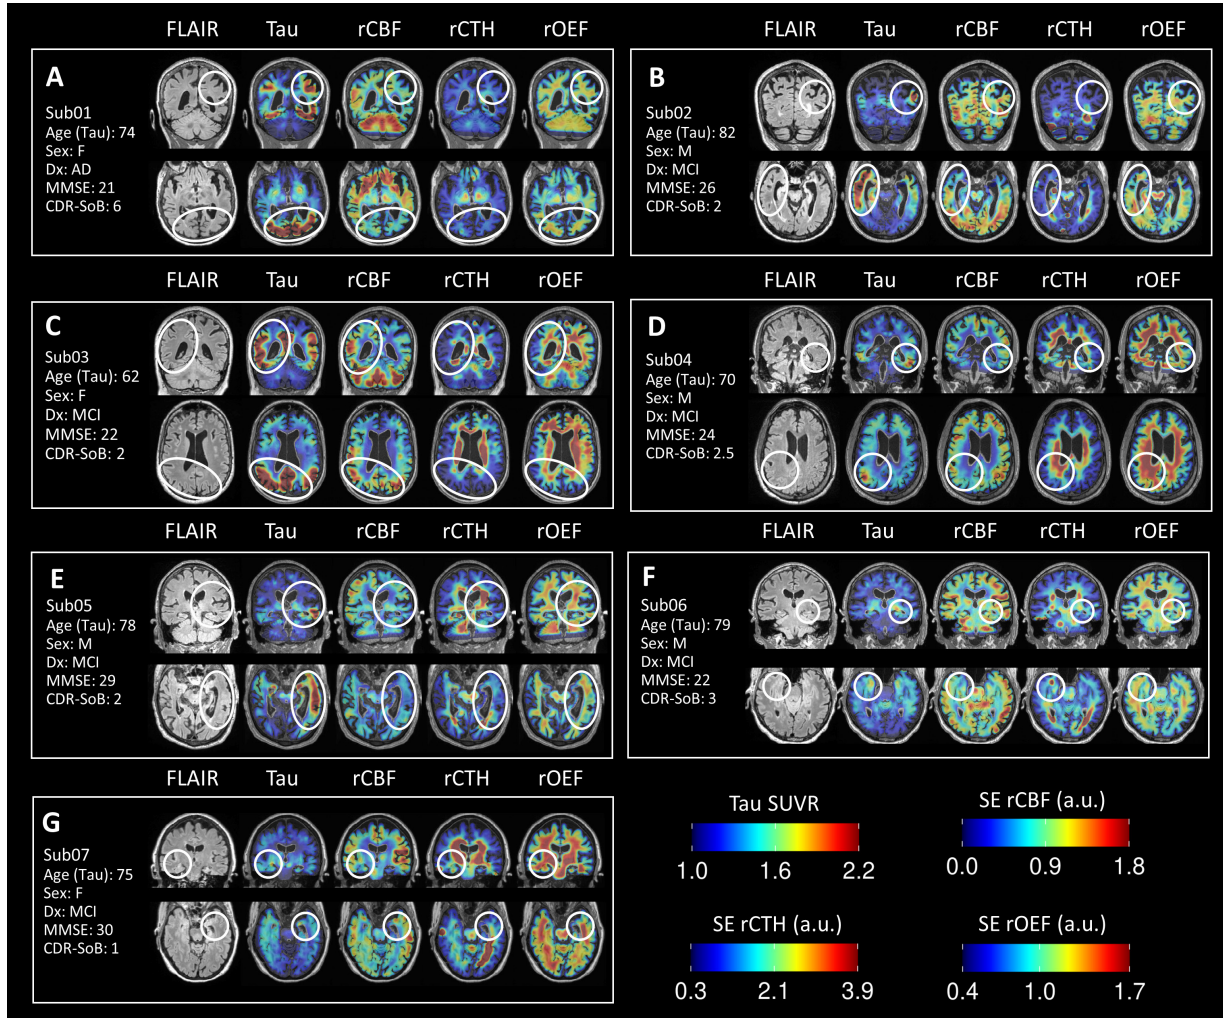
Representative slices showing FLAIR, tau-PET SUVR, rCBF, rCTH, and rOEF parametric maps for each subject. All volumes are presented in individual subject space. White ovals highlight regions with high tau-PET signal and/or noteworthy SE-DSC microvascular patterns. a.u. = arbitrary units. (A higher resolution / colour version of this figure is available in the electronic copy of the article).
